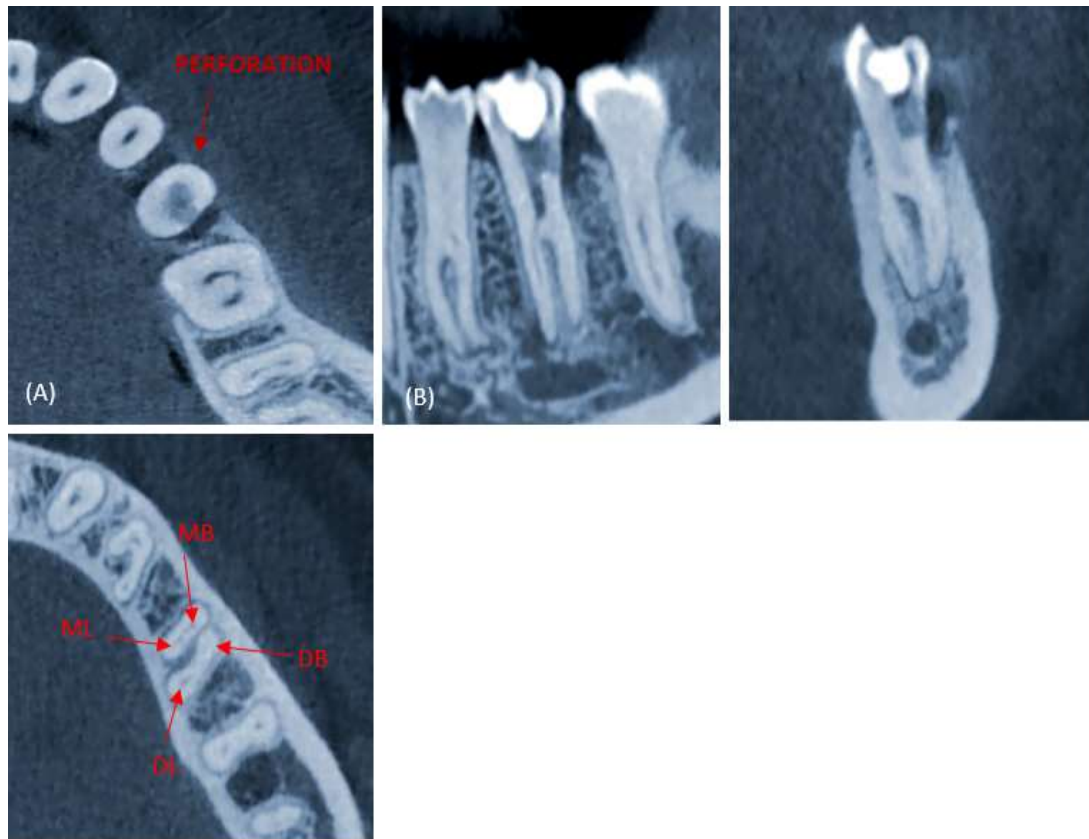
a: Axial view of Cone beam computed tomography (CBCT) (perforation site), b: Sagittal plane, c: Coronal plane, d: Axial plane (MB: Mesiobuccal Canal, ML: Mesiolingual Canal, DB: Distobuccal Canal, DL: Distolingual Canal)
